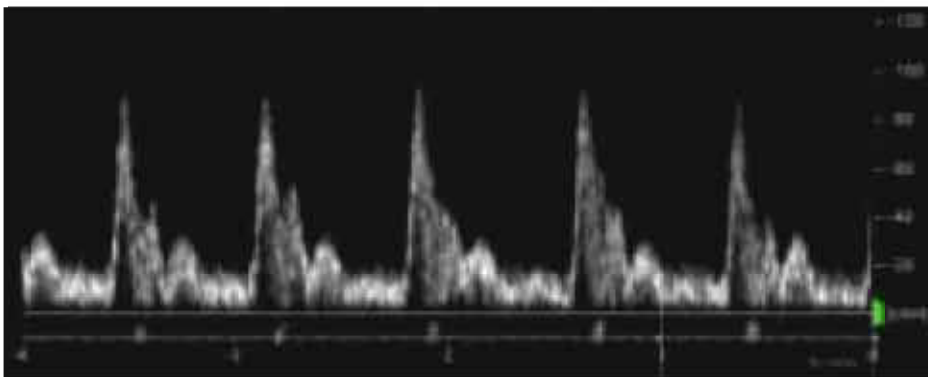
An example of a sonogram, visualizing the time-dependent velocity profile in the common carotid artery of a healthy volunteer. This image was made for the in-vivo study, mentioned in chapter 8.
